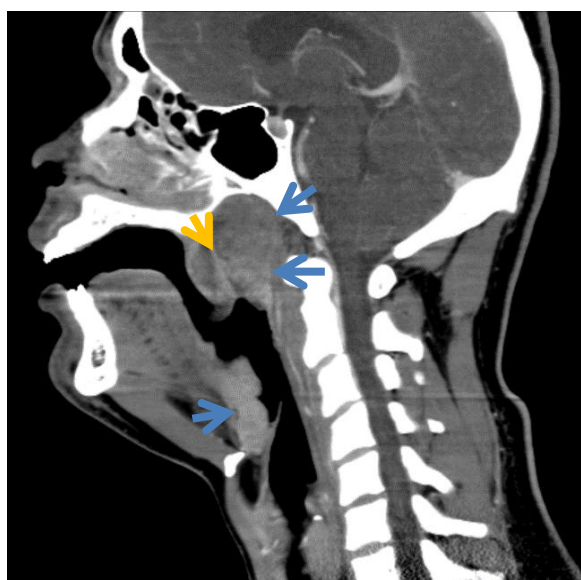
A Sagittal CT scan of the face and neck with contrast shows marked diffuse swelling of the Waldeyer's tonsillar ring (blue arrows), resulting in severe narrowing of the nasopharyngeal airway (orange arrow).
